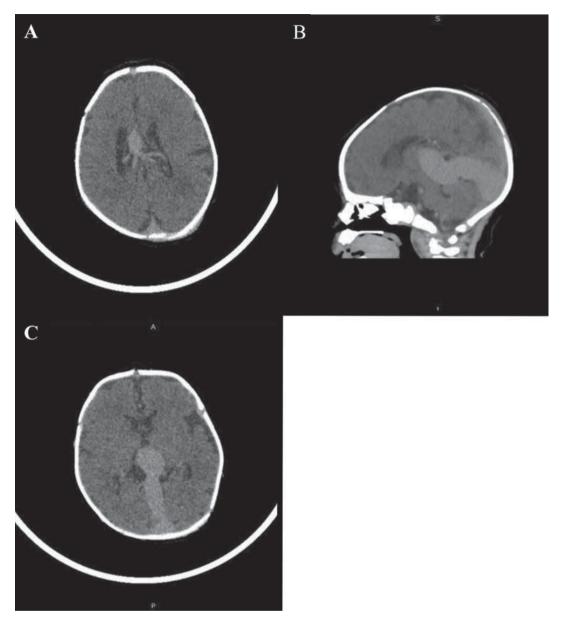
Computed tomography of the brain: (A and B) mid-sagittal and coronal images showing a hypoechoic lesion in the region posterior to third ventricle; (C) the vessels feeding the aneurysm and mildly dilated lateral ventricles.
